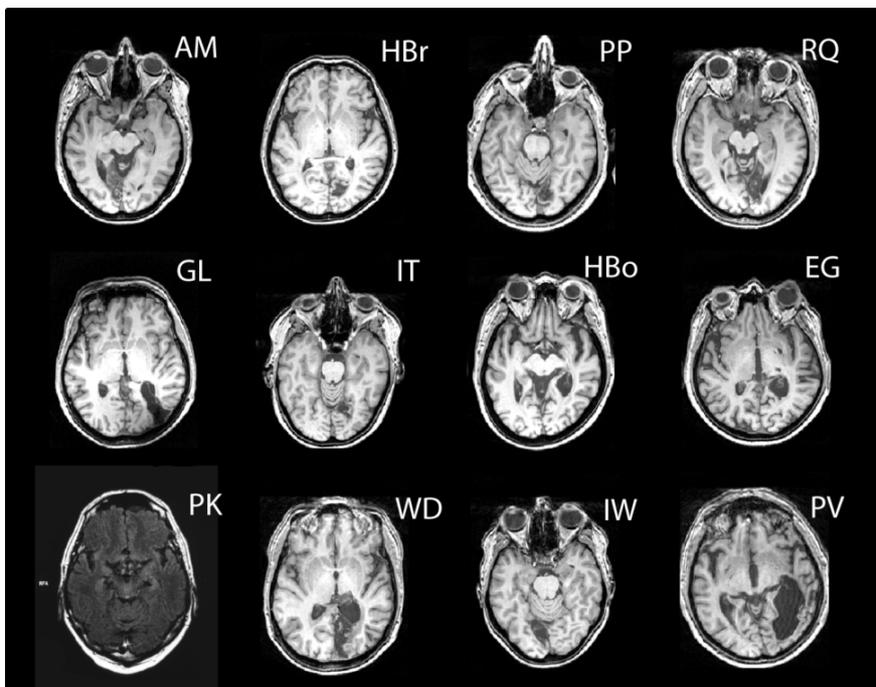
Anatomical T1-weighted MRI-scan slices that optimally show the lesions of the patients. Scans are shown in neurological convention (L=L; R=R). For PK, the slice is a T2-weighted MRI-scan, shown in radiological convention (L=R; R=L).
